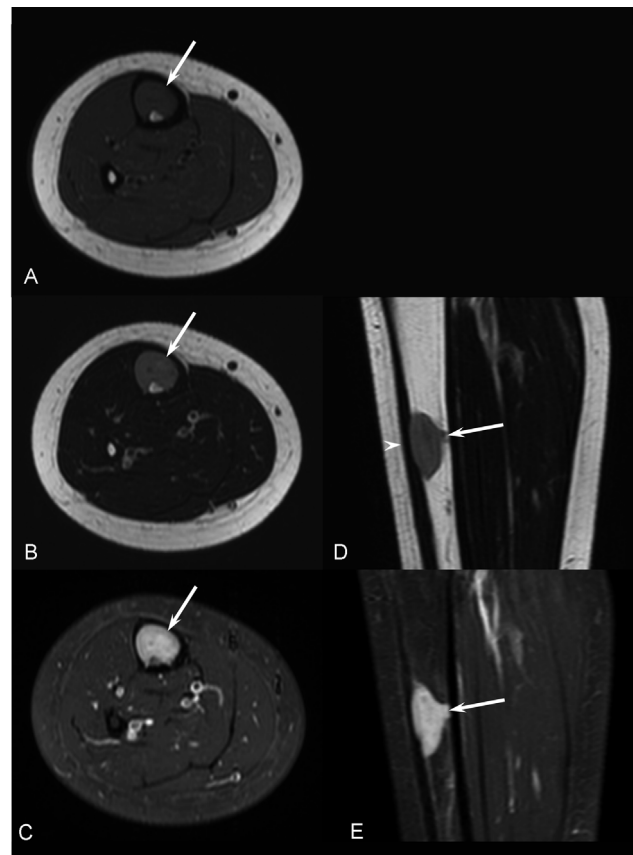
A 5-year-old girl child patient with osteofibrous dysplasia of the right tibia. Magnetic resonance imagings show a well-demarcated, eccentric, homogeneous lesion appearing hypointense (arrow) on T1-weighted image (A), mildly hyperintense (arrows) on T2-weighted images (B/D) with cortical thinning (arrowhead), enhancing intensely (arrows) on fat-suppressed contrast-enhanced T1-weighted images (C/E).
